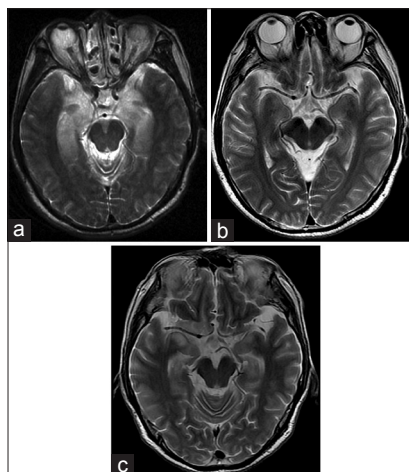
Brain magnetic resonance imaging screens in anti-gamma-aminobutyric-acid B receptor encephalitis: (a) revealed bilateral increased T2 signal in the medial temporal lobe at the first admission; (b) showed milder increased T2 signal 1 months after the first discharge; (c) revealed the lesion worsen again at the second admission
